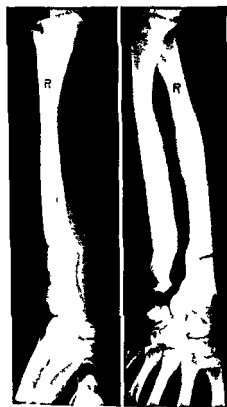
Case 1 Showing the roentgenographic end result of the corrective osteotomies 8 weeks after operation
